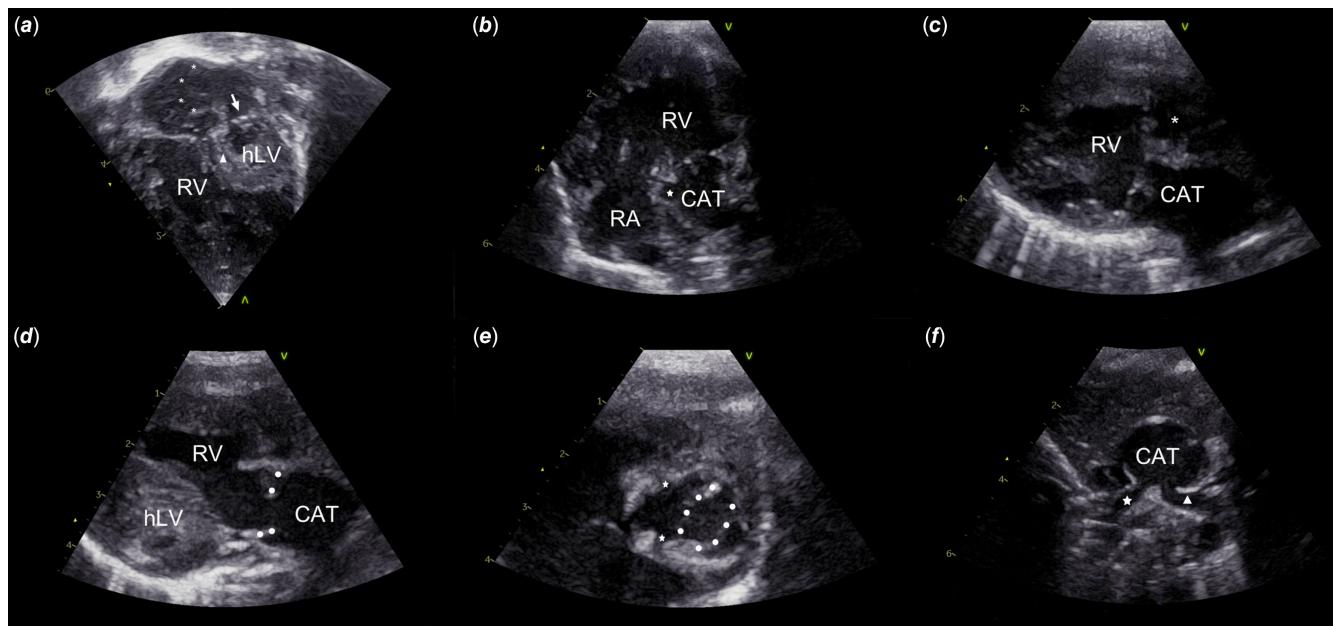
Echocardiographic findings, still images. a: Apical 4-chamber view: hypoplastic left ventricle (hLV), normally developed right ventricle (RV), atrial septum (asterisks) aneurysmatically protruding into the right atrium; mitral atresia (arrow); intact ventricular septum (triangle). b: Apical long axis, modified: inlet-outlet of RV; protuberance (asterisk) from the CAT to the right as an abortive ‘paleo-aortic remnant’; right atrium (RA). c: Parasternal long-axis view: the solitary outlet (CAT) from the right ventricle is positioned more posteriorly, the infundibulum of the RV (asterisk) ends. d and e: Parasternal long (d) and short (e) axis: hypoplastic left ventricle (hLV) without outlet; slightly dysplastic, opened trunical valve (dots depicting the commissures); coronary arteries from the right sinus (asterisks). f: Parasternal short axis: CAT with origins of the pulmonary arteries; right pulmonary artery (asterisk) with stenosis, left pulmonary artery unobstructed (triangle).
